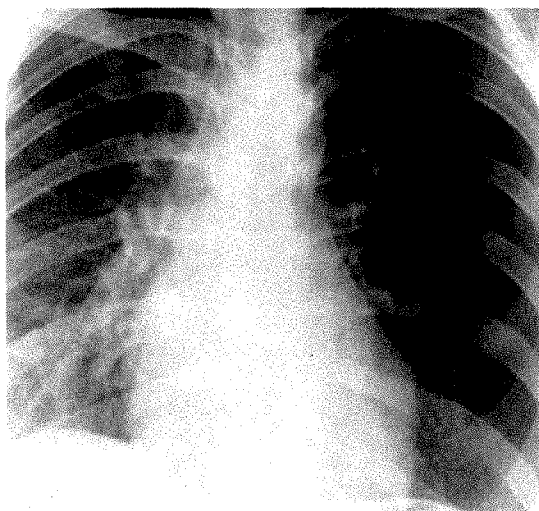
Expiration roentgenogram shows normal clouding of the right lung field without increase in density on the left side. There is no significant mediastinal shift.
